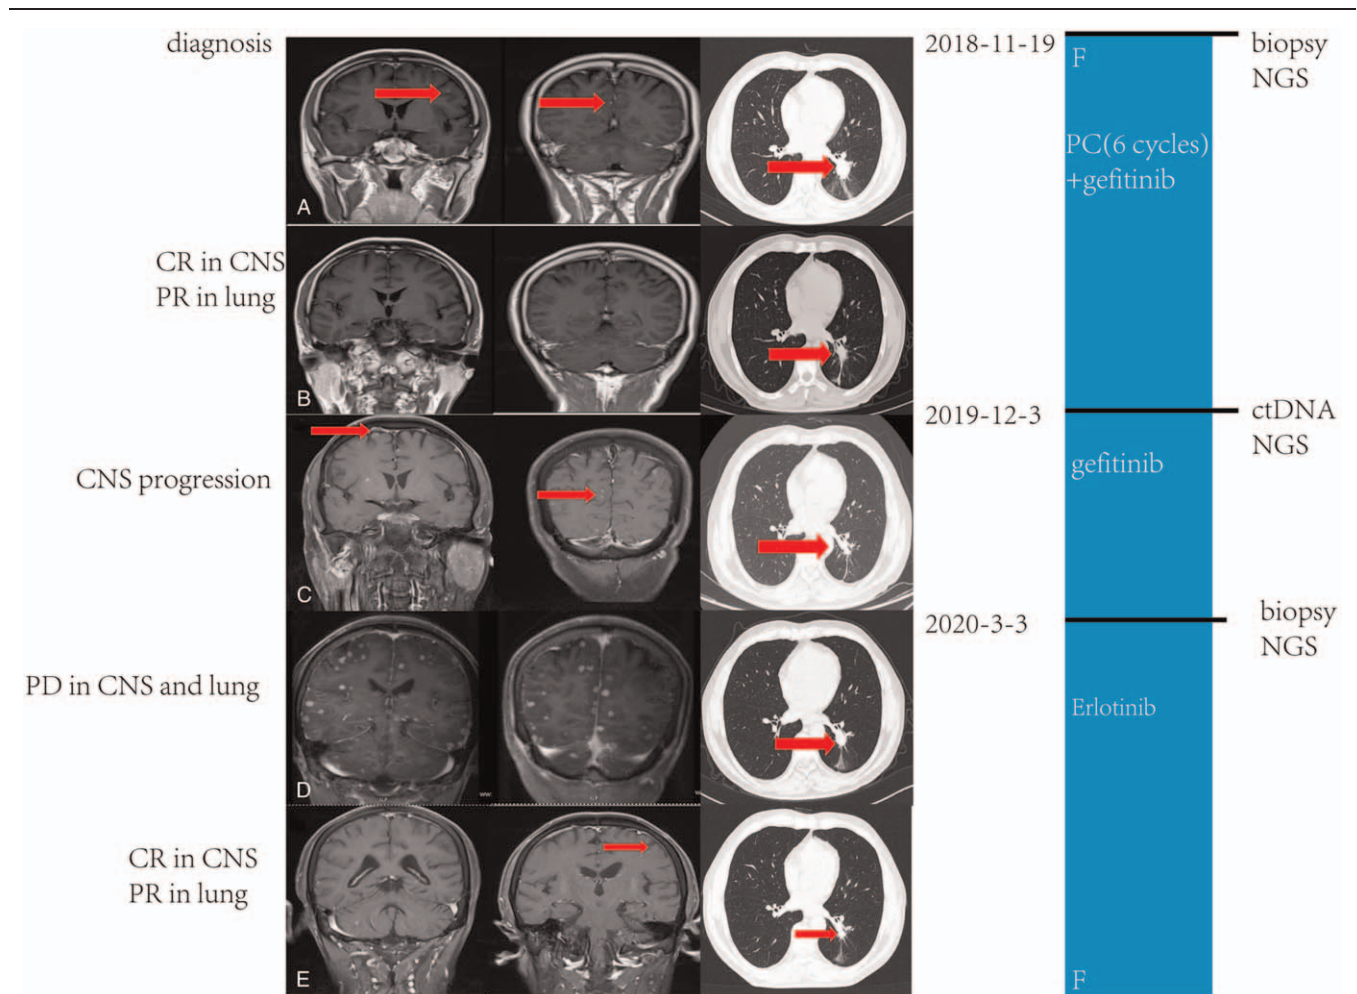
Timeline and effect of EGFR-TKI treatments. (A) Baseline images of CT and MRI at diagnosis; (B) Brain metastases complete remission (CR) and original lung mass partial response (PR) after six cycles of PC (pemetrexed 1 g and carboplatin 500 mg) and one year of gefitinib treatment; (C) Brain metastases progressed gefitinib treatment was administered; (D) Images of CT and MRI before erlotinib treatment; (E) Brain metastases CR and lung mass PR after erlotinib treatment was administered; (F) Treatment timeline; CNS = central nervous system; CT = computed tomography; EGFR, epithelial growth factor receptor; MRI = magnetic resonance imaging; PD = progressive disease; TKI = tyrosine kinase inhibitor.
